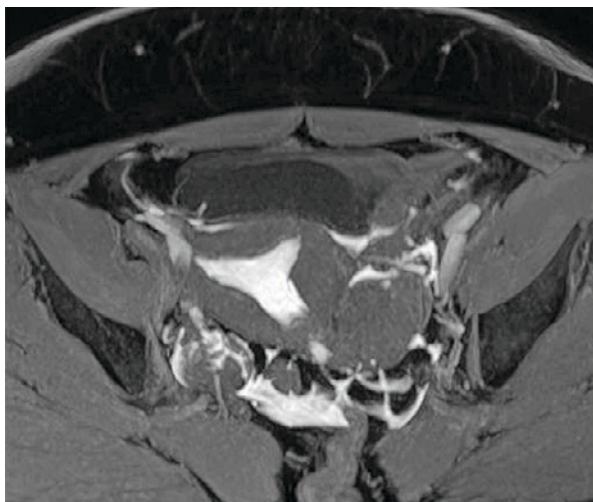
Multi-planar reconstruction from 3D T1-weighted images acquired after MR-HSG. The contrast solution is visible within the uterine cavity, around the ovaries, and in the pouch of Douglas.
